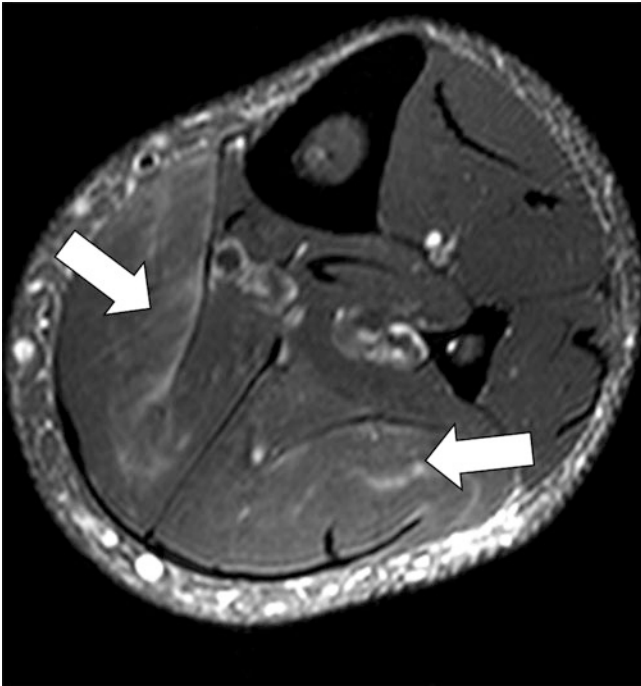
Axial fat-saturated T2 MR image of the left calf in a 31-year-old male with severe calf pain after cross-fit workout. The feathery edema in the posterior compartment musculature (white arrows) is consistent with delayed onset muscle soreness (DOMS). This finding may persist for months following the initial insult
